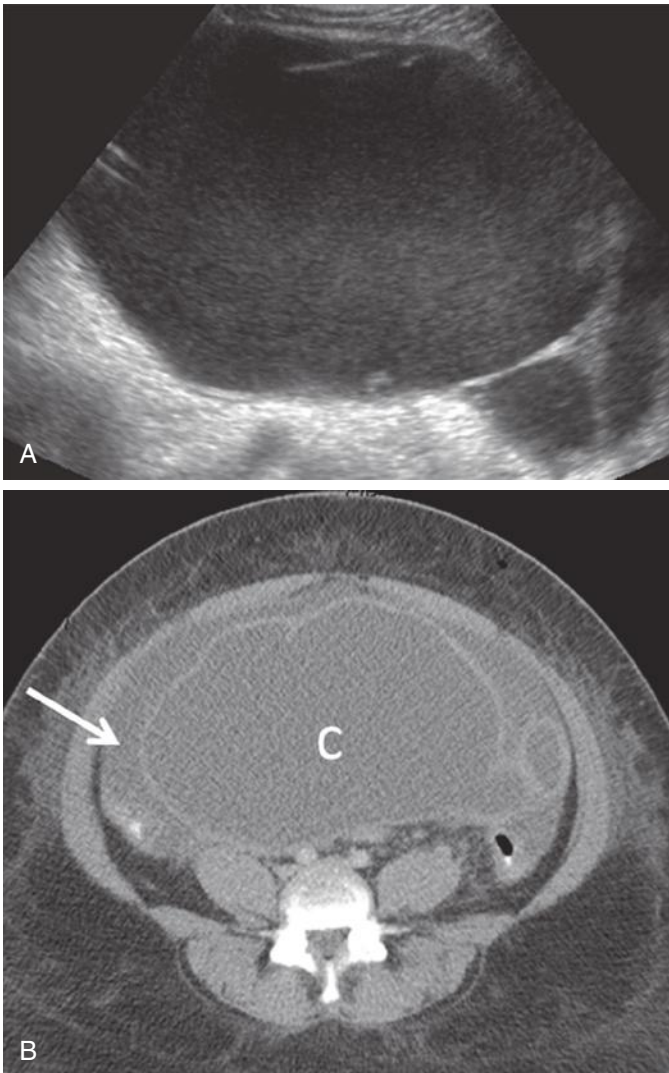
Infected endometrioma with rupture in a patient with abdominal pain and sepsis. A, Ultrasound image shows a large complex cystic mass with low-level echoes and incomplete septation. B, Computed tomography demonstrates the large cystic mass (C) with incomplete septation anteriorly and associated ascites (arrow). Ruptured endometrioma with superinfection was confirmed at surgery.
